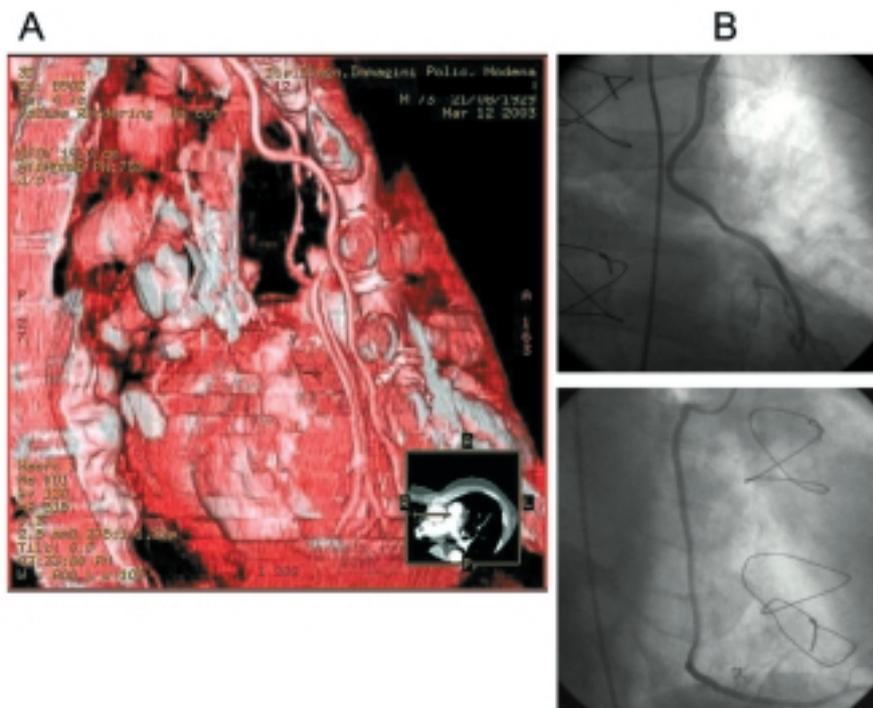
A: this is a right oblique volume rendering image in a patient with two patent grafts; the arterial bypass, immediately below the sternum, is directed towards the left anterior descending artery, and the venous graft to the right coronary artery. It is possible to note the “perfect” correspondence between multislice computed tomography and coronary angiography in the assessment of the graft patency. B: antero-posterior projection (top), with selective angiographic visualization of the left internal mammary artery, and right oblique projection (bottom), with clear opacification of the bypass for the right coronary artery.
